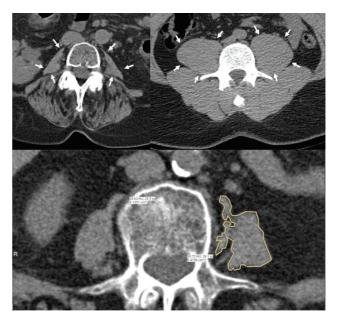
Psoas muscles (outlined by white arrows) measured on axial computed tomography at the level of L4 in patients with sarcopenia (top–left) and healthy muscle mass (top–right), with total psoas area normalizing to 376 and 1,366 mm²/m², respectively. The psoas muscles are outlined (bottom) demonstrating the technique of cross-sectional psoas area measurement, highlighted on the left psoas muscle.
